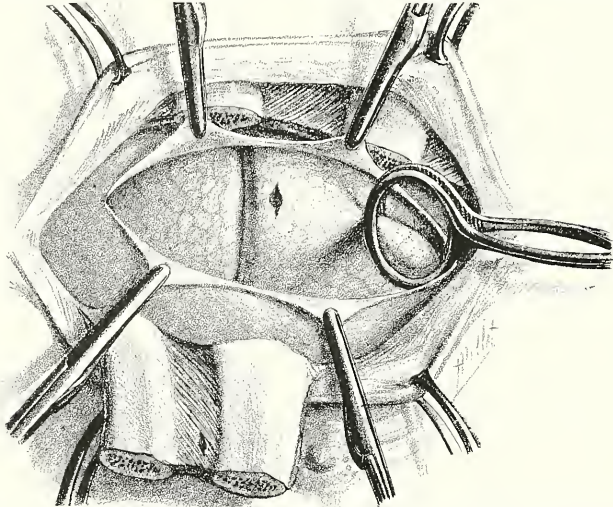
WOUND OF LUNG BY A CUTTING INSTRUMENT, WHICH ENTERED THE THIRD INTERCOSTAL SPACE IN THE PARASTERNAL LINE.
